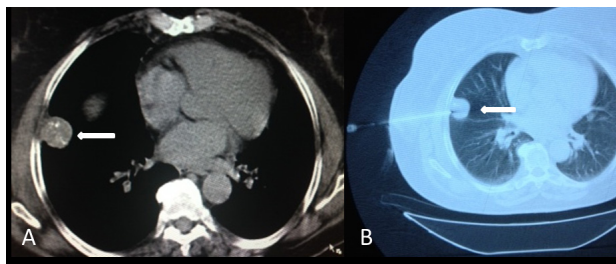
Axial CT image demonstrates a peripheral located lesion with smooth margins having coarse calcifications- fat density (A). Computed tomography guided trans thoracic fine needle biopsy of the lesion is seen (B)
